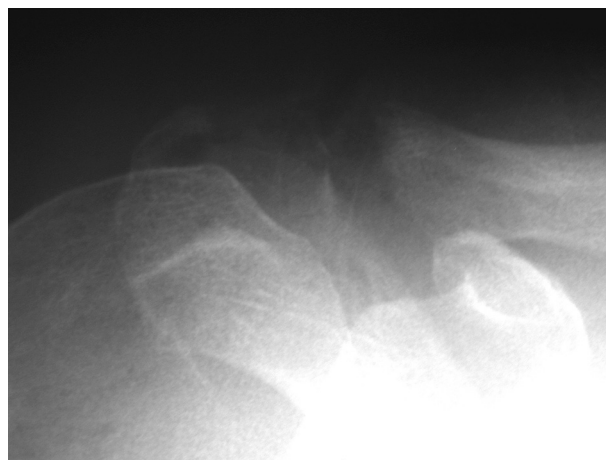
Radiograph of the right shoulder, Zanca view, showing arthrosis of acromioclavicular joint.
